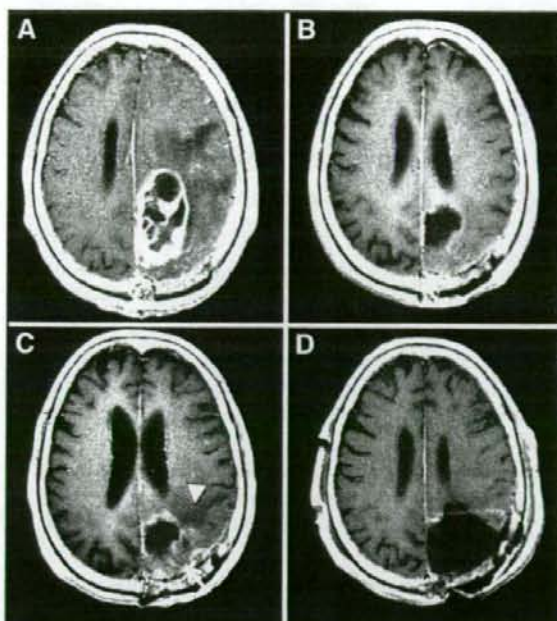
Serial Gd-enhanced T1-weighted MRI scan in Patient 1. A, just before the second operation. B, 20 months after BNCT. No enhanced lesion and no perilesional edema were observed. C, 14 months after BNCT. White arrow shows the new Gd-enhanced lesion. A white arrowhead indicates the perilesional edema, which was not observed in B. D, just after the third operation. The Gd-enhanced lesion was completely resected by the third operation.
